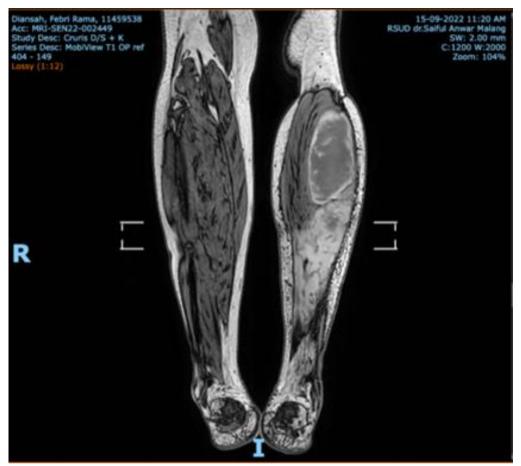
Magnetic resonance imaging (MRI) of the left lower leg revealed a well-defined cystic mass within the intramuscular region of the gastrocnemius and soleus muscles. The lesion appeared hypo- to slightly hyperintense on T1-weighted imaging (T1WI), and hyperintense on both T2-weighted imaging (T2WI) and proton density fat-saturated (PDFS) sequences. Diffusion-weighted imaging (DWI) demonstrated restricted diffusion. Post-contrast sequences showed heterogeneous enhancement. Associated bone marrow signal changes were observed in the adjacent left crural bone.
